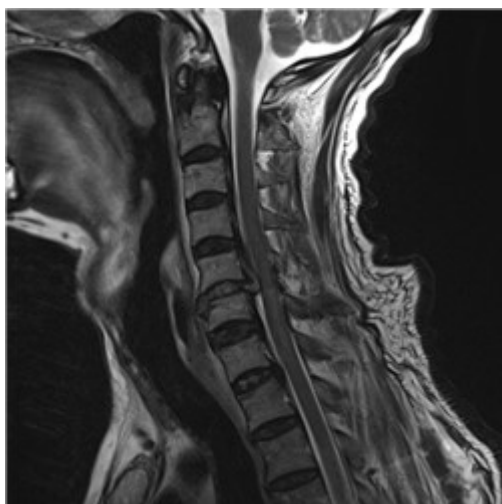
The patient's cervical magnetic resonance image.
